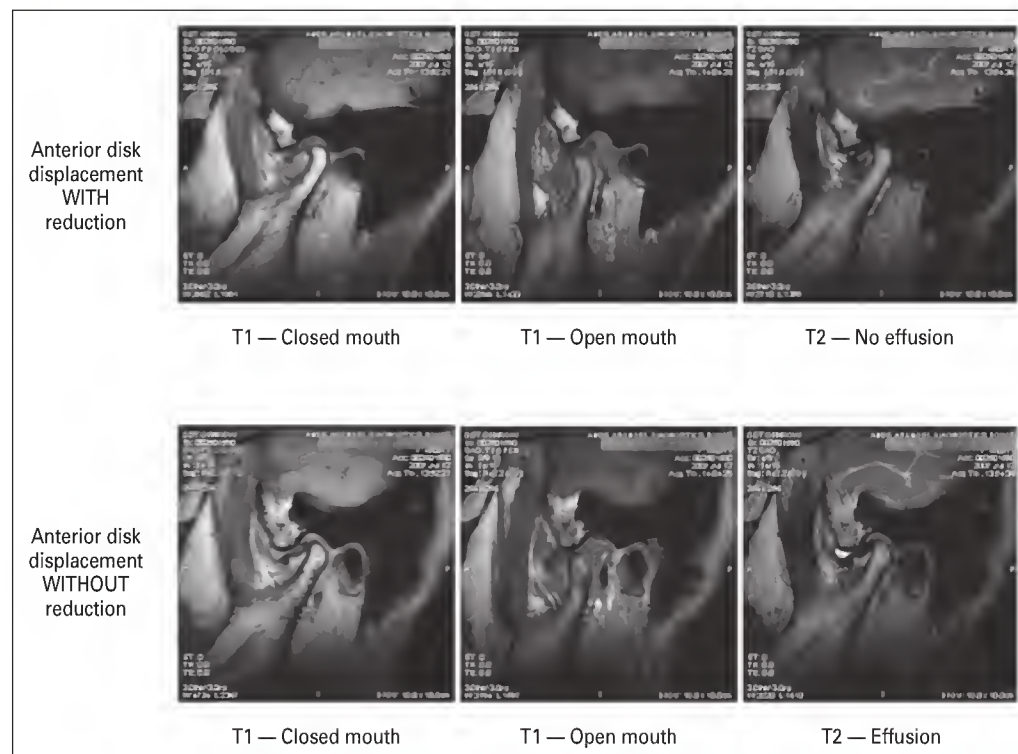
Magnetic resonance images depicting disk displacement.
